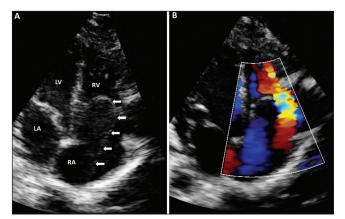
Two-dimensional (a) and two-dimensional color flow Doppler (b) echocardiography images in four chamber views from the apical window. (a) The cor-triatriatum dexter membrane (arrows) which is partially prolapsing across the tricuspid valve to the right ventricle during diastole. (b) Eccentric tricuspid valve inflow (red color) from the outer part of the right atrium to right ventricle. The blue color represents the systemic venous blood flow that is diverted back to right atrium by the cor-triatriatum dexter membrane. LA: Left atrium, LV: Left ventricle, RA: Right atrium, RV: Right ventricle
